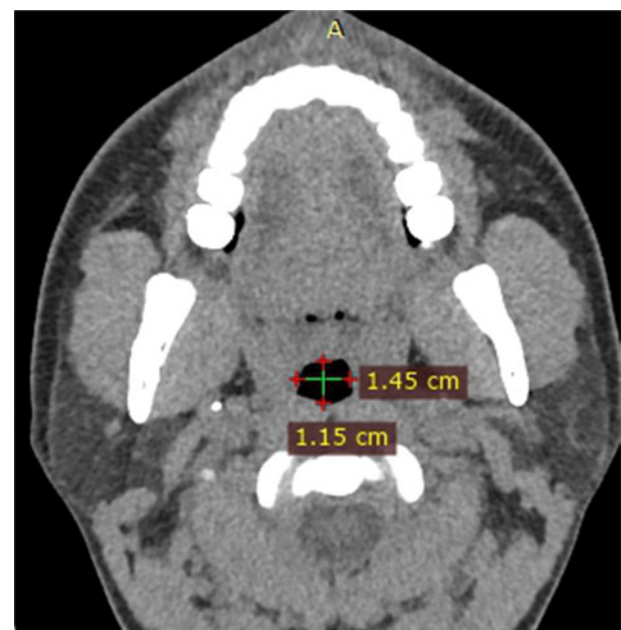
Axial computed tomography scan of the upper airway showing the minimum anteroposterior dimension and lateral dimension at the level of the minimum cross-sectional area of the retropalatal area. A = anterior
